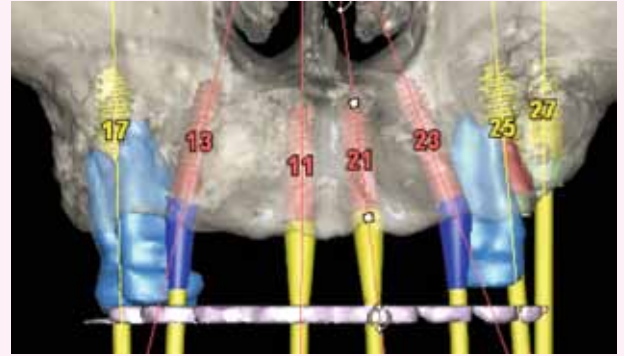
Cone Beam CT scan. Interactive planning using the Simplant software showing the positioning of the implants within the available bone as well as the selection of the abutments, which lie within the prosthetic envelope.
